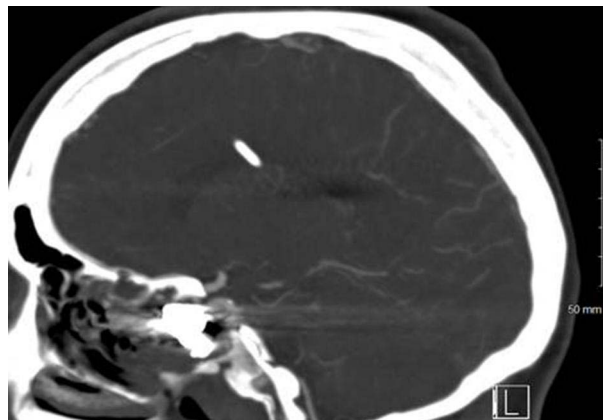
Sagittal view of the head CT showing persistent occlusion of the pseudoaneurysm and internal carotid artery patency.
